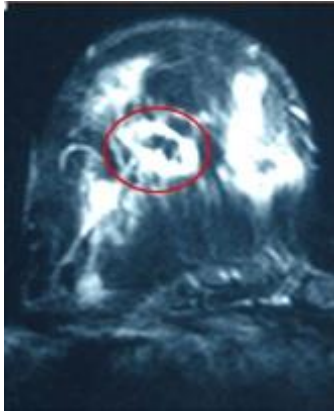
Breast magnetic resonance imaging showing multiple mass enhancements; a mass (encircled) with a rim enhancement
